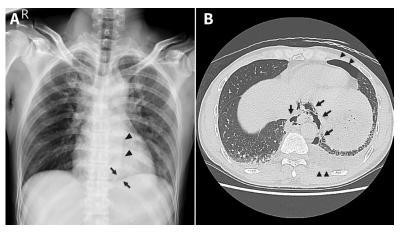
Boerhaave syndrome in a 46-year-old man. (A) Chest radiograph showing Naclerio's V sign, which is the presence of air outlining the left, lower, lateral mediastinal border (arrows), with periaortic air streaks lateral to the descending aorta and above the left diaphragm (arrowheads). Naclerio's V sign confirms pneumomediastinum. (B) Chest computed tomography scan showing pneumomediastinum (arrows) and left hydropneumothorax (arrowheads) suggestive of esophageal rupture.
